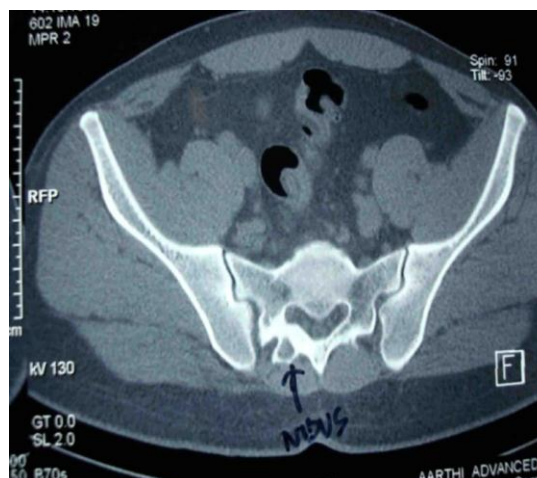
CT showing nidus in the second sacral arch .
